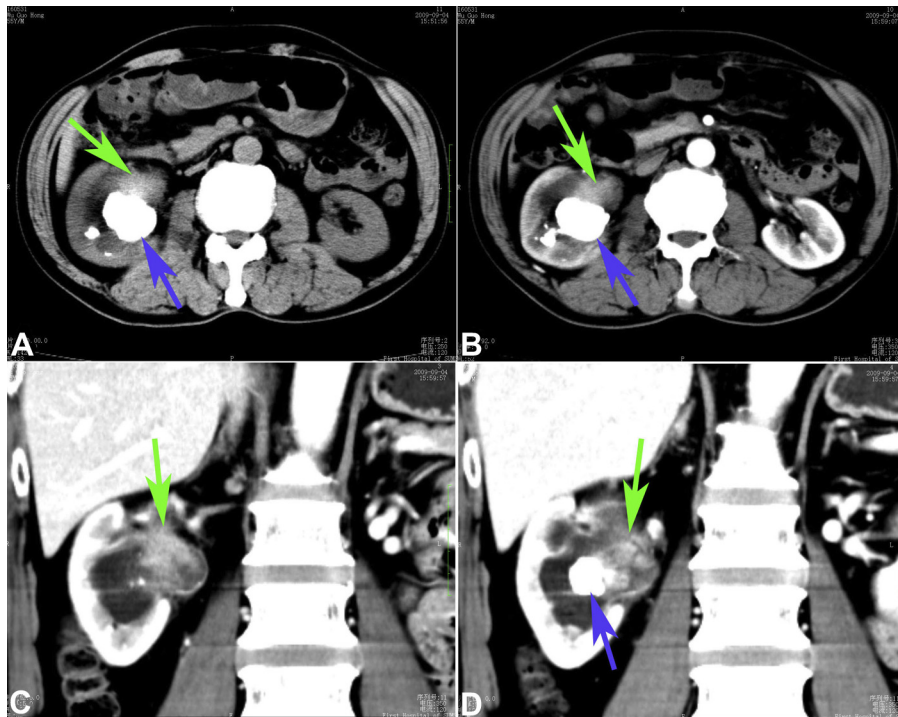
Computed tomographic plain scan shows multiple stones within the right renal pelvis and calyceal, an irregular soft tissue mass in the ureteropelvic junction (A). Uneven enhancing visualization appears in the mass along with an upper-ureteric thickening in the enhancement scanning (B). Right hydronephrosis reconstruction was obtained in images (C, D).
